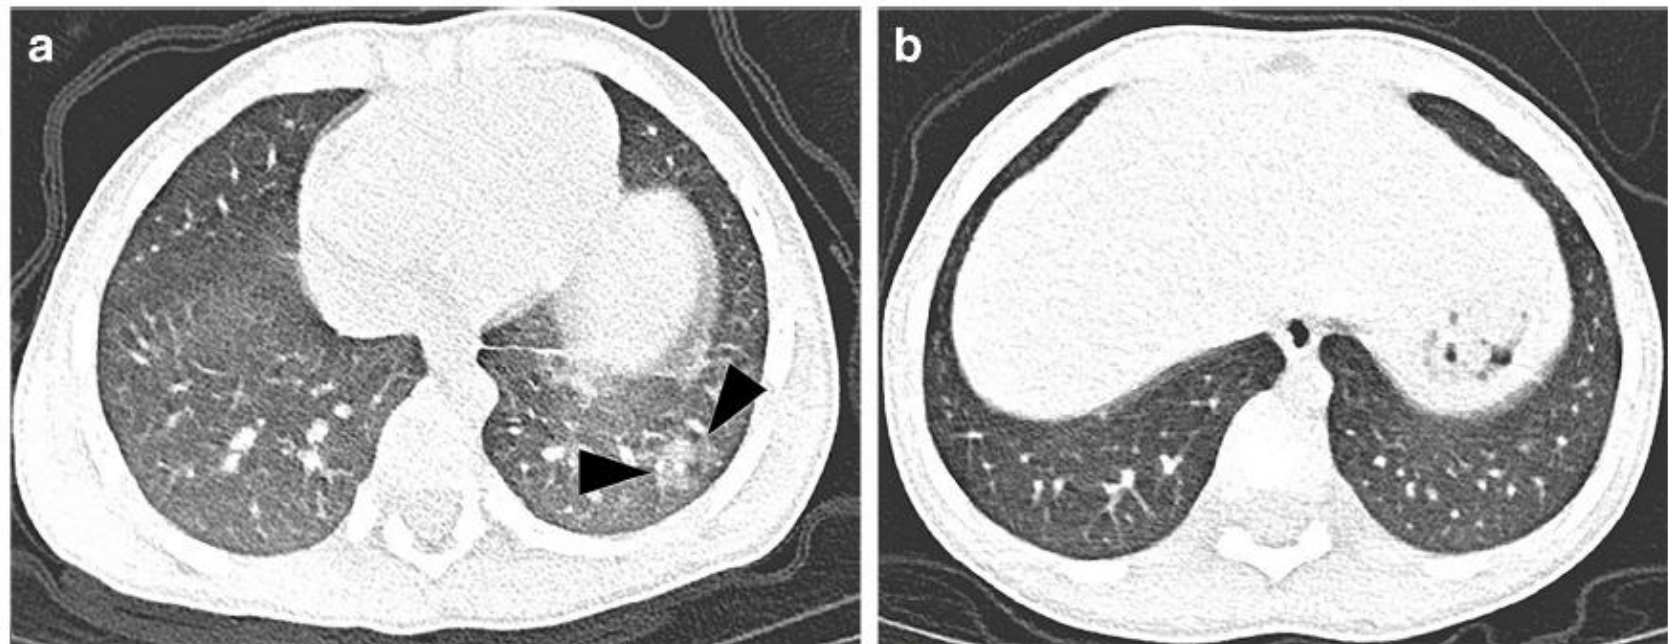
Axial non-enhanced chest CT in a 3-year-old boy (Patient 3 in Table 1). a Nine days after onset of symptoms, there is patchy ground-glass opacification (*arrowheads*) in the left lower lobe. b Seven days subsequently, during antiviral treatment, the appearances have normalised
